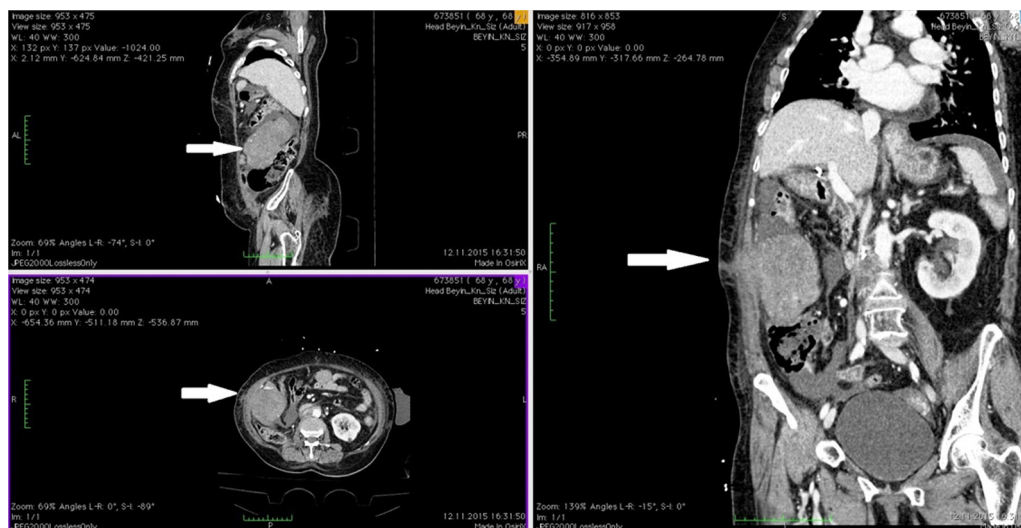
CT imagine of mass.
